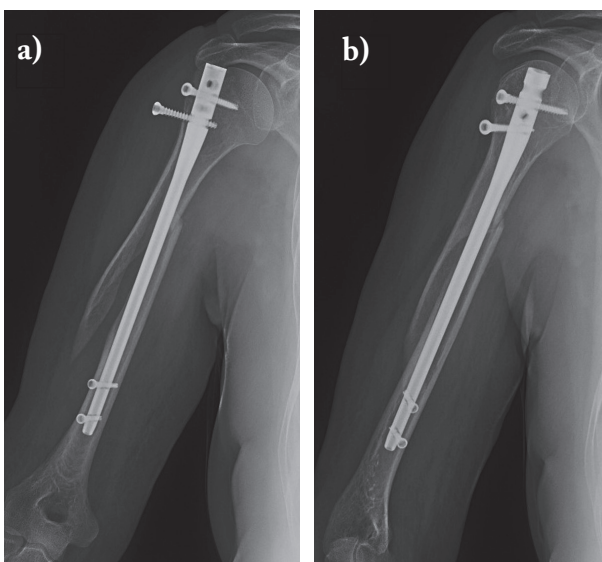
a, b. X-rays one month after surgery. No signs of bone callus. Mobilization of one of the proximal screws
